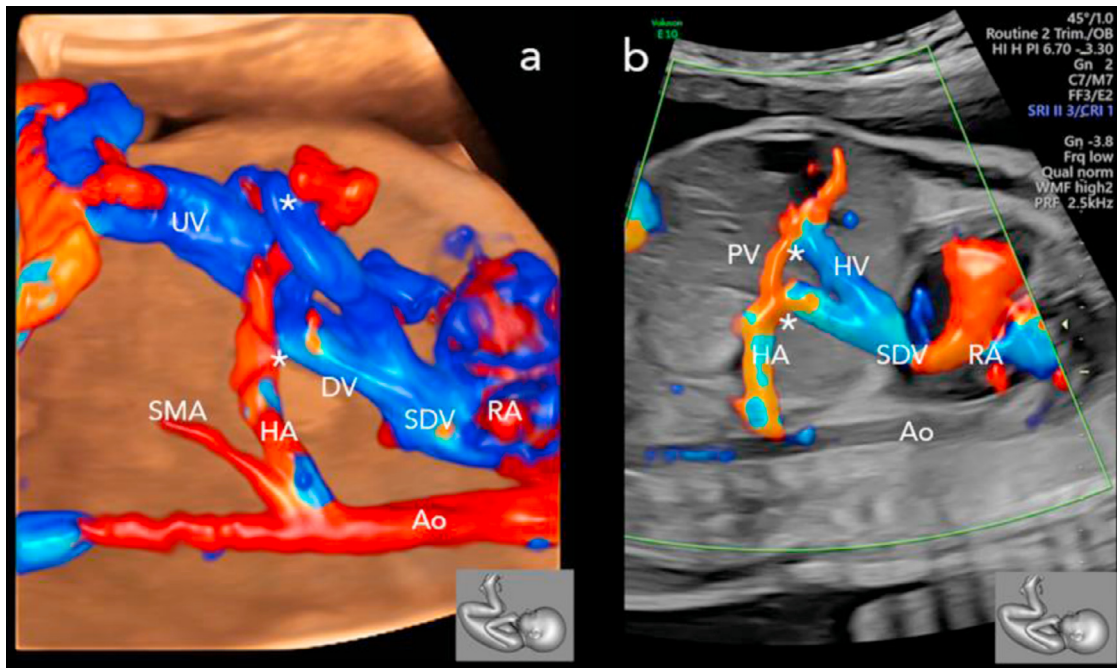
Twenty-seven-year-old primigravida at 27 weeks of gestation. (A) 3D multiplanar reconstruction & (B) 2D cross sectional sagittal colour doppler ultrasound evaluation of the portosystemic shunts (*). UV, umbilical vein; DV, ductus venosus; SMA, superior mesenteric artery; HA, hepatic artery; SDV, subdiaphragmatic vestibulum; RA, right atrium; Ao, aorta; PV, portal vein.
